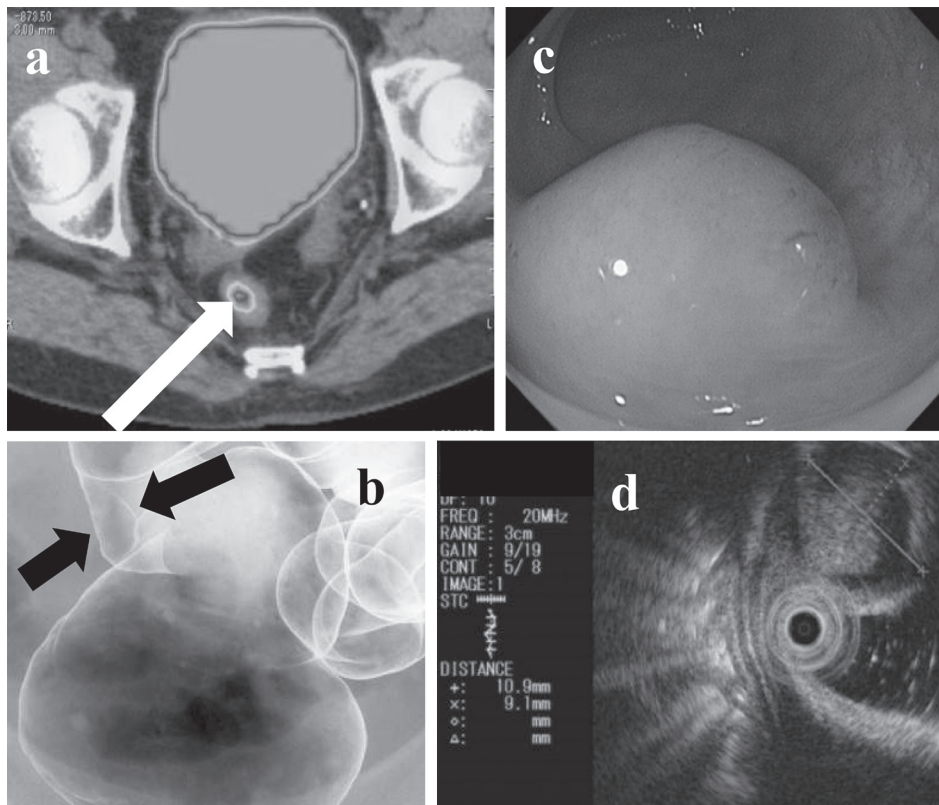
A metastatic rectal tumor is discovered via positron emission tomography-computed tomography (PET/CT), barium enema, colonoscopy, and endoscopic ultrasonography.
